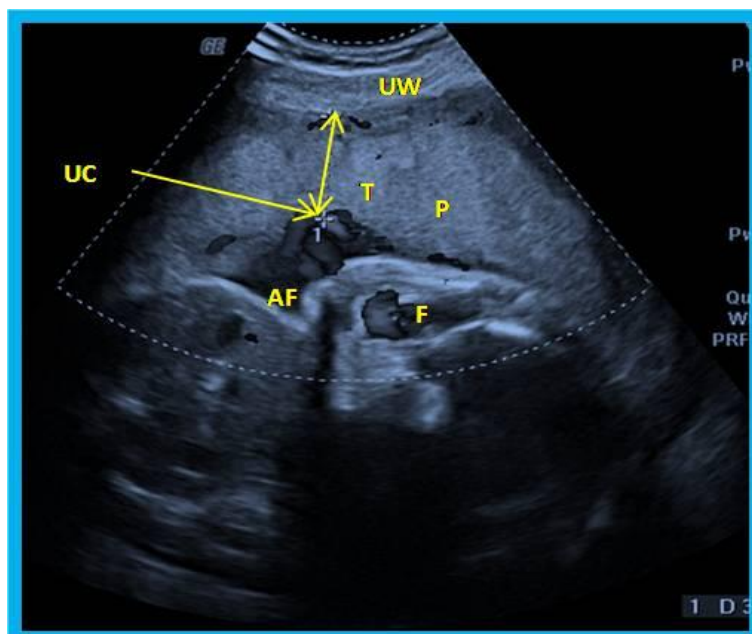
Ultrasonogram showing landmarks for measuring thickness of placenta. (P= Placenta, UW= Uterine wall, T= thickness of placenta, UC= Umbilical cord, AF= Amniotic fluid, F= Foetus).
